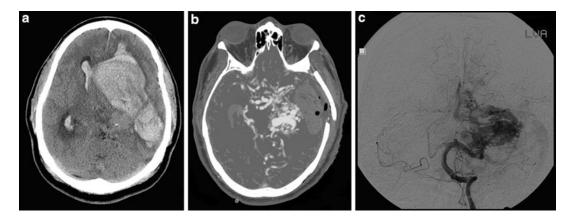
(a) Noncontrast head CT demonstrates a large left fronto-temporo-parietal intracranial hemorrhage with associated intraventricular hemorrhage, mass effect, and midline shift, (b) contrast-enhanced cerebral CT angiogram
